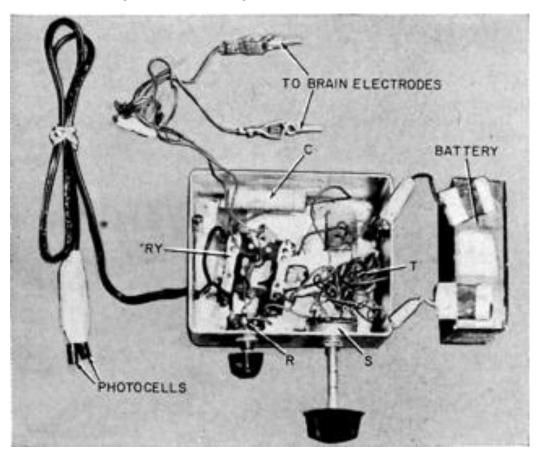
AS REPRINTED IN (LEWIS & ROSENFELD, 2016): THE IMAGE PROCESSOR OF THE FIRST CHRONICALLY IMPLANTED VISUAL PROSTHESIS MADE BY JOHN C. BUTTON AND TRACEY PUTNAM. FROM "ELECTRICAL STIMULATION OF THE BRAIN AND THE DEVELOPMENT OF CORTICAL VISUAL PROSTHESES: AN HISTORICAL PERSPECTIVE", BY PHILIP M. LEWIS, JEFFREY V. ROSENFELD, 2016, BRAIN RESEARCH, 7(1), P. 212, COPYRIGHT 2016 BY CREATIVE COMMON ATTRIBUTION 4.0 (HTTPS://CREATIVECOMMONS.ORG/LICENSES/BY-NC-ND/4.0/)
